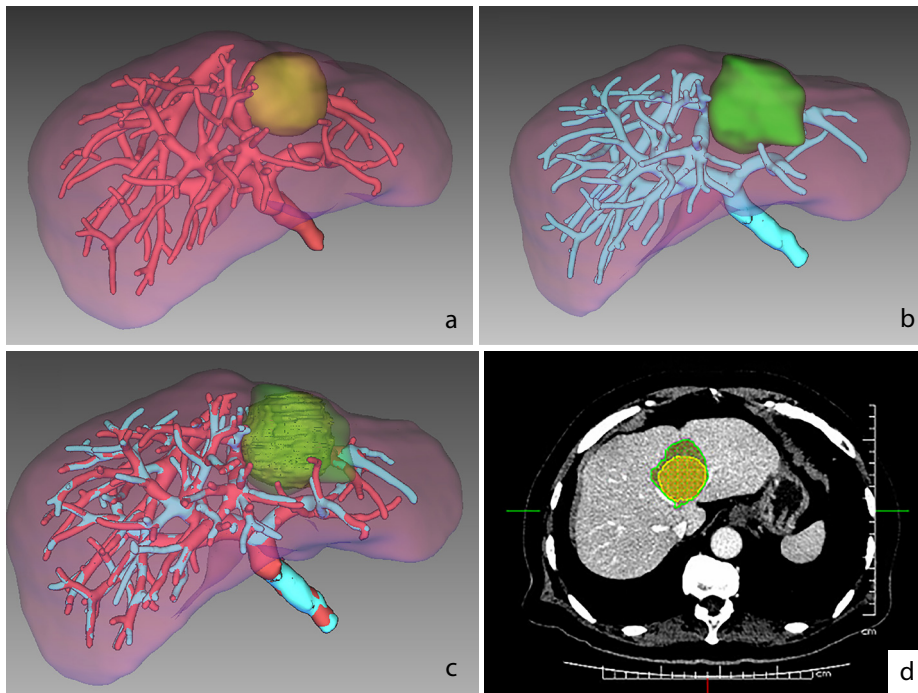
A hepatocellular carcinoma tumor located in contact with large vessels (the left and middle hepatic veins) in an 87-year-old man was treated by radiofrequency ablation (RFA) combined with multipronged ethanol ablation: (a) a computed tomography (CT) fusion obtained before performing combined ablation showed a lesion with a diameter of 4.2 cm in segment IV (marked in orange); (b) a CT fusion obtained one month after combined ablation showed the ablation zone (marked in green), which confirmed the complete ablation of the tumor; (c) a CT fusion showed that the tumor was successfully covered by the translucence ablation zone (green); (d) the pre-RFA tumor was overlaid on the post-RFA images. The ablation zone (marked in green line) covered the tumor (marked in yellow line). The minimal ablative margin was 0 cm at the side of the ablation zone in contact with the left and middle hepatic veins.
